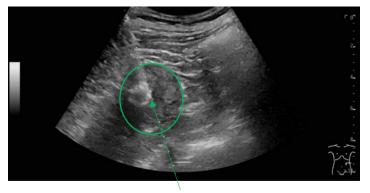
ultrasound image of the percutaneous renal mass biopsy. green circle: mass in the left kidney; arrow: tip of the biopsy needle.
